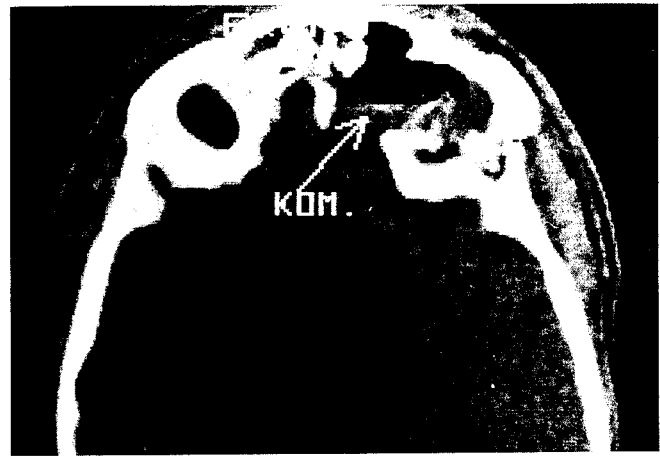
This computed tomographic scan shows the findings of the same patient (from Fig. 3) 21 days later. There is an encephalocele in the right orbit as a complication.
